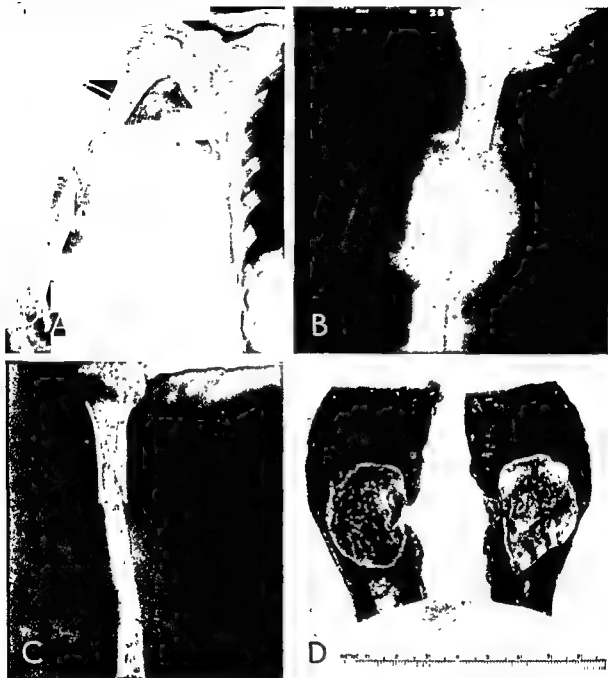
A, Cyst of humeral shaft which recurred after two curettages and tibial transplants; B, same case immediately after segmental resection and massive substitution by tibial transplant; C, same case four months after operation (note that the transplant shows roentgenographic evidence of viability); D, gross appearance of the resected portion of the humerus.
